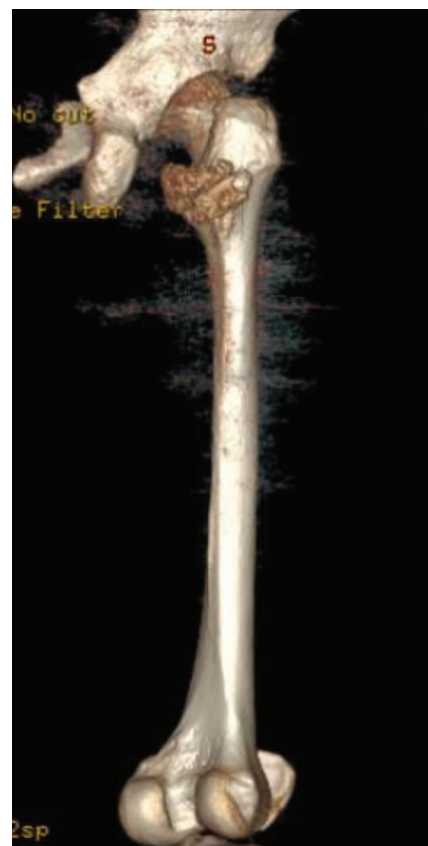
Case 14: a 34-year-old male with osteochondroma; preoperative three-dimensional computed tomography view showing mass lesion at posterior femoral neck
